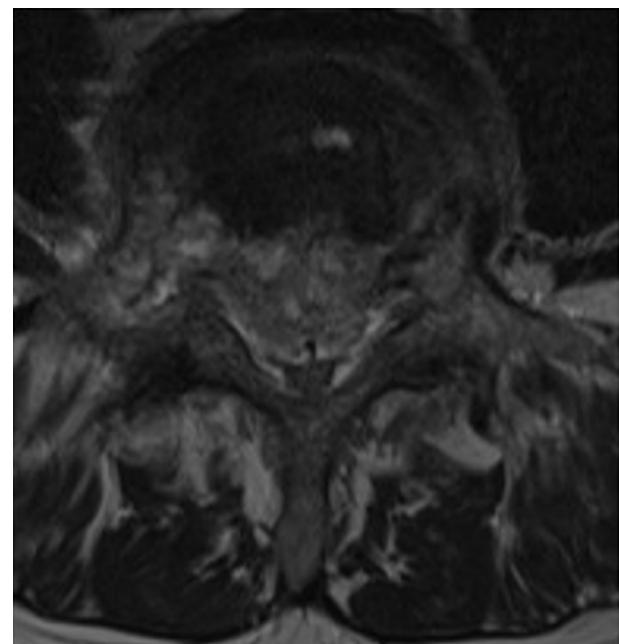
Axial T2-weighted magnetic resonance imaging demonstrates retropulsion of the posterior margin of L5 into the anterior epidural space causing severe central canal stenosis at L5 and S1.
